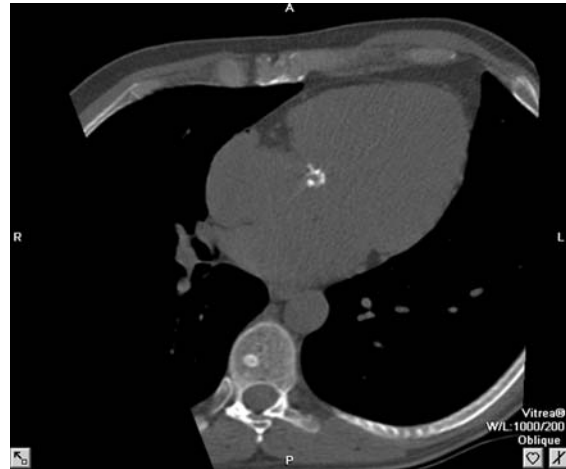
Horizontal long axis reconstruction from a non-contrast-enhanced electron-beam CT examination in a 30 year old man with coarctation of the aorta (not shown) and congenital bicuspid aortic valve. Mild curvilinear calcification near the geometric center of the heart characterizes this abnormal leaflet.
